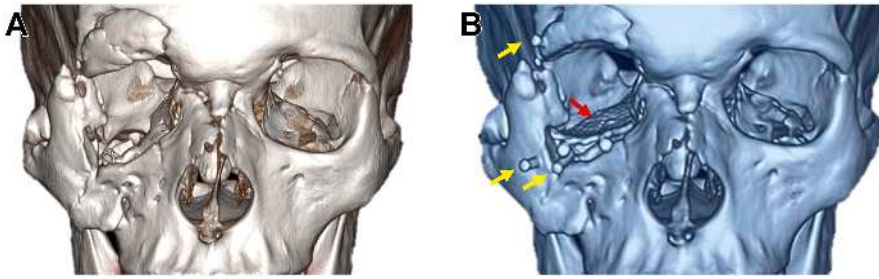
The 3D CT images demonstrating (A) preoperative status of the deformity with gross displacement of the right zygomatic complex and SORs, (B) postoperative status with intraorbital reconstruction using a preformed anatomic titanium implant (*red arrow*), which was manually customized on an STL model. Onlay, PEEK implant (invisible on CT) used for SOR and zygoma has been fixed with titanium screws (*yellow arrows*).
